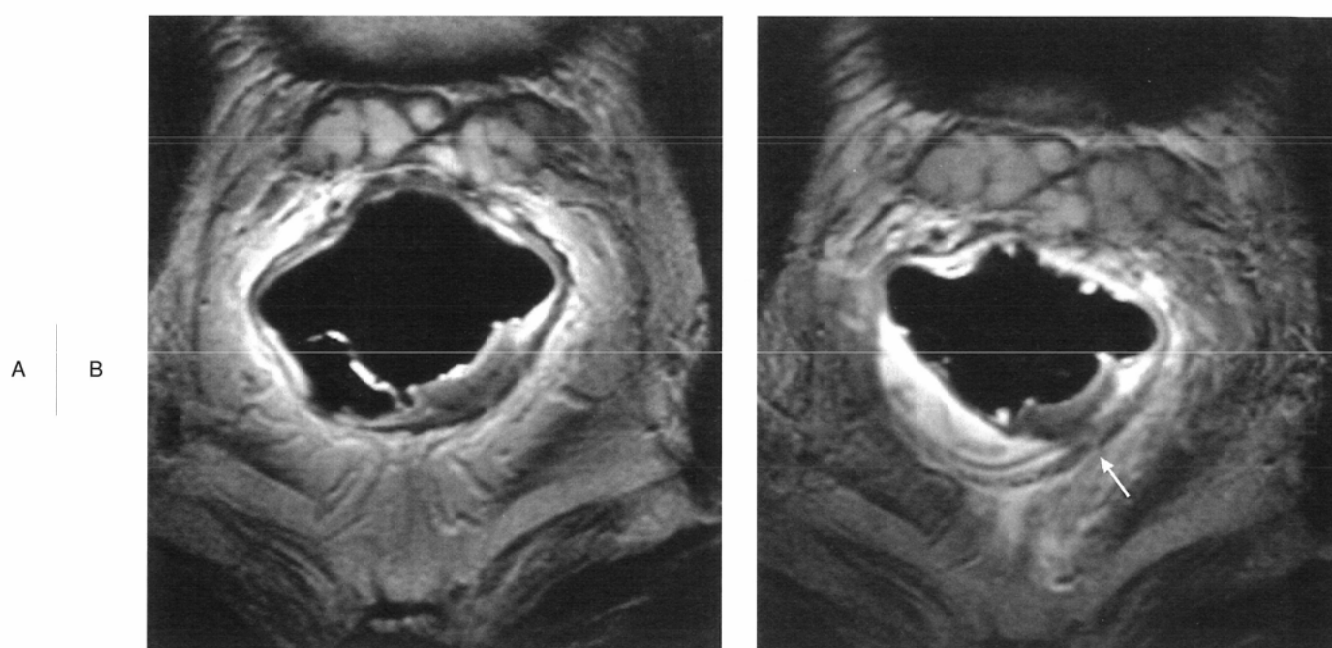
A minute cancerous invasion is better appreciated after submucosal saline injection (B: arrow) than before the procedure (A) (T2-weighted images).
